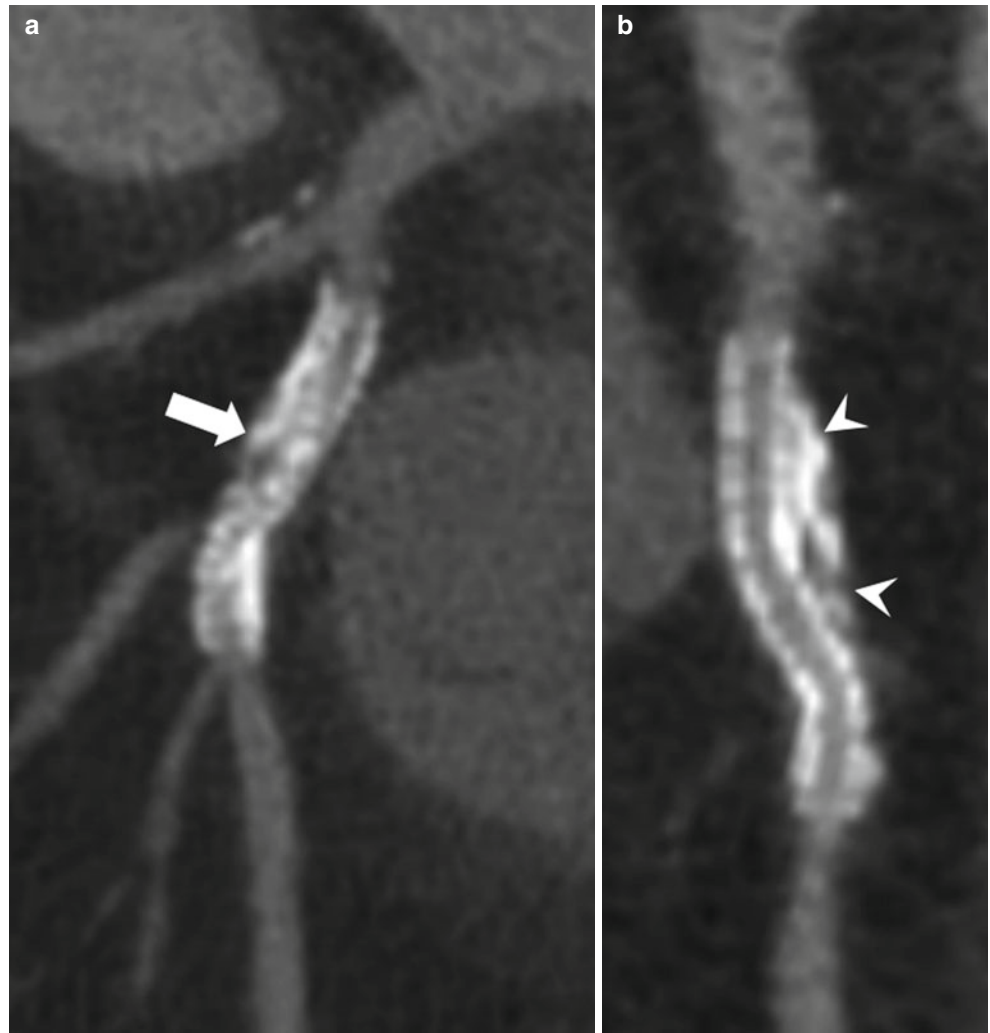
Usefulness of thick-slab MIP image for diagnosis of mechanical deformity of stent. (a) Curved planar CT image of sirolimus-eluting stent (Cypher) shows fractures (*arrows*) in the midportion of the stent. Lumen of the stent was patent. (b) On the thick-slab MIP image, stent fracture was delineated more clearly (*arrows*)
